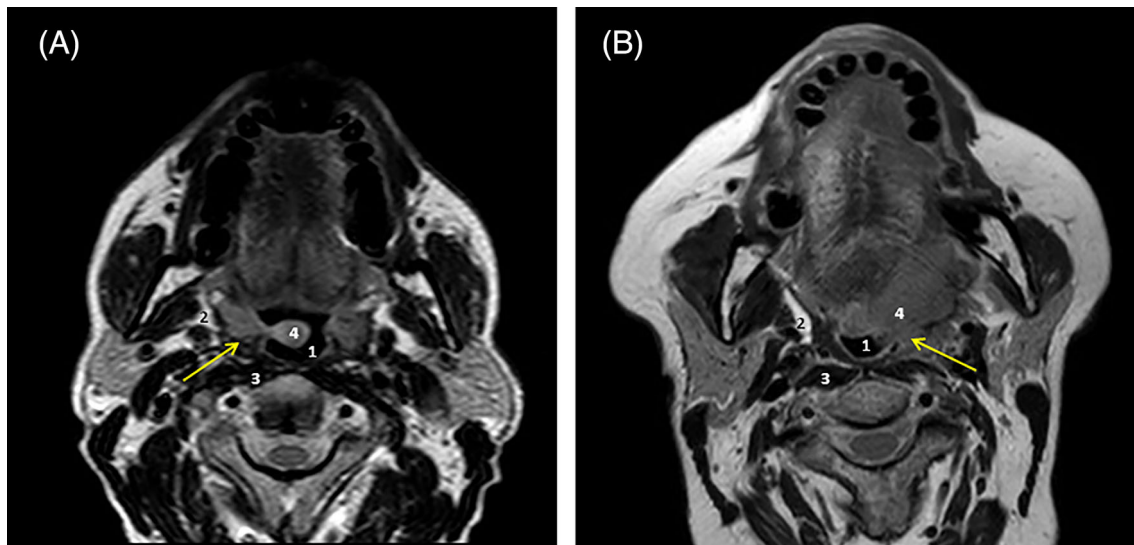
Pretreatment MR imaging in patients with OPSCCs. (A) Axial T2WI of a 72-year old male with right-tonsillar SCC (arrow) showing no signs of SPCM: note the normal contour and thickness of the SPCM similar to the contralateral side. (B) Axial T2WI of a 68-year old male with left-tonsillar SCC revealing thinning of the SPCM due to the tumor (arrow) and protrusion of the tumor into the parapharyngeal space. 1: pharyngeal lumen; 2: parapharyngeal space; 3: prevertebral muscles; 4: primary tumor. MR, magnetic resonance; OPSCC, oropharyngeal squamous cell carcinoma; SPCM, superior pharyngeal constrictor muscle [Color figure can be viewed at wileyonlinelibrary.com]
